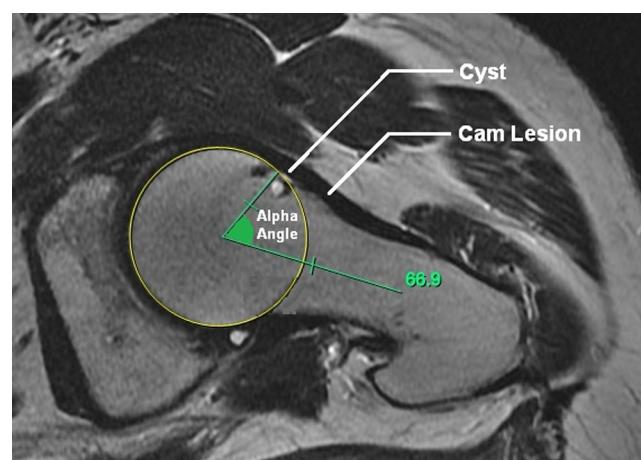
Axial MRI of left hip showing high α angle (66.9°) with cam lesion. Subchondral cyst is also seen at the anterior femoral head.
